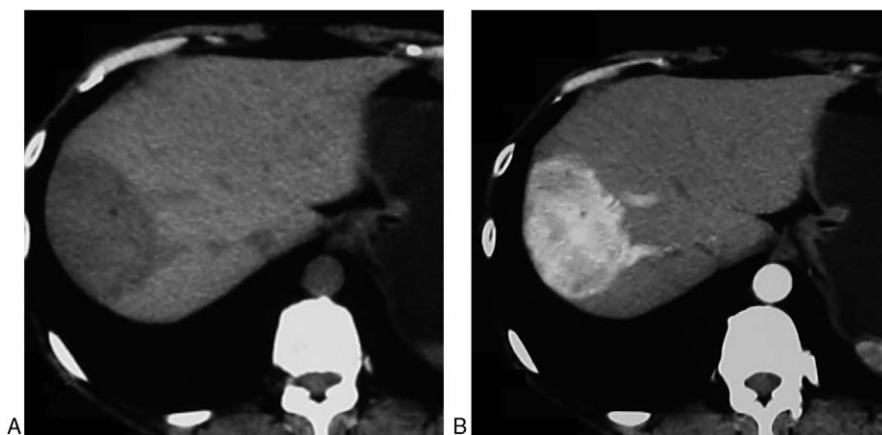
Abdominal CT scan showed a well-defined hypodense mass with a maximum diameter of 7.5×5.0 cm located mainly in the S8 segment in the normal scan (A) and apparent enhancing in arterial phase (B). CT=computed tomography.
